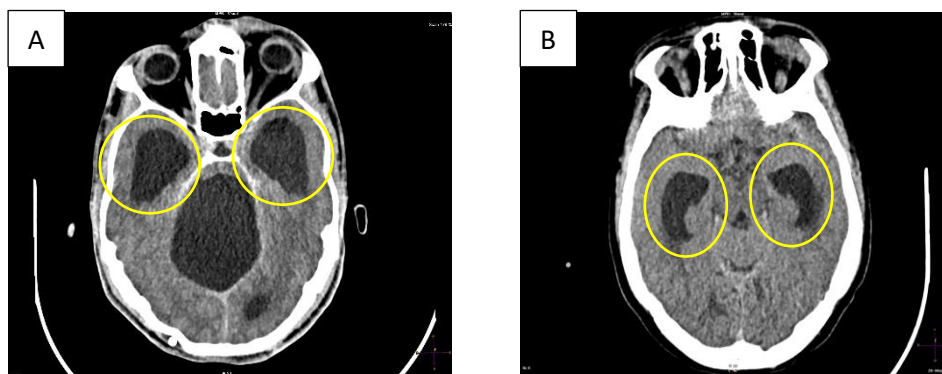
CT scans showing the temporal horns of patients with A) chronic HCP and B) acute HCP, circled in yellow.
